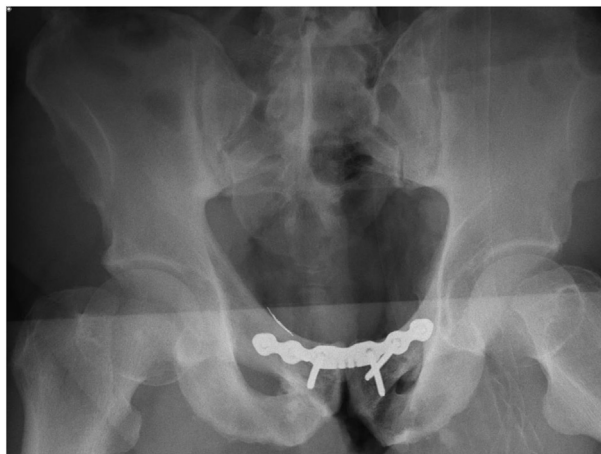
Intra-operative supine radiograph taken immediately after plate fixation of the symphysis.
